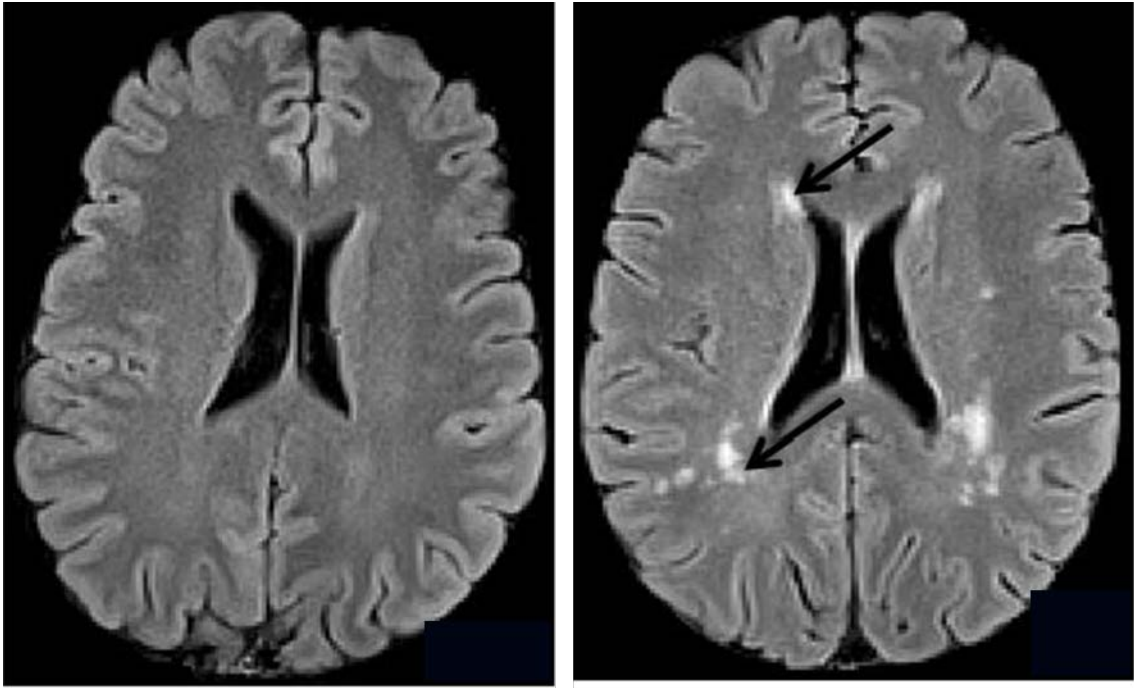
Left: FLAIR image of 49 y.o. female without type 1 diabetes, no visible WMH;
